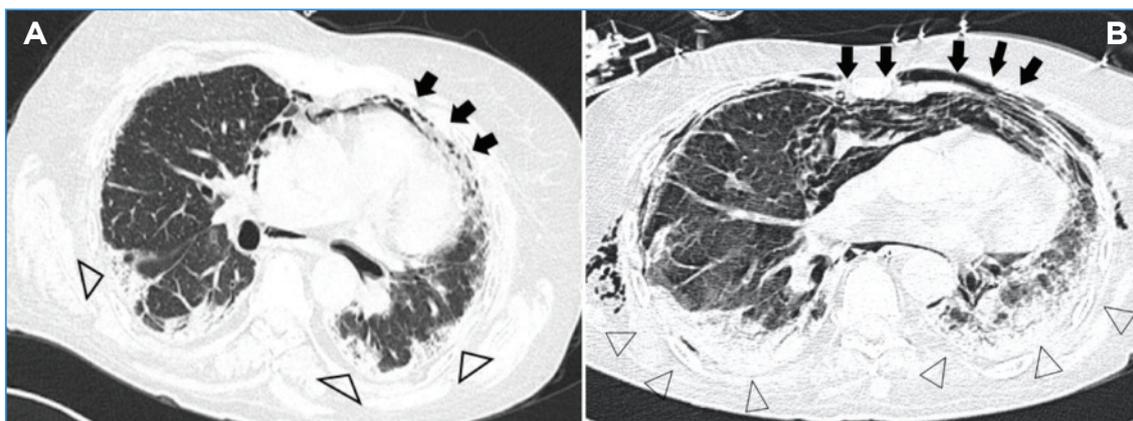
A) Axial image of chest computed tomography 4 months after pneumomediastinum (PnM) diagnosis with a significant reduction of the size of the PnM (black arrows). NSIP (arrow heads). B) Axial image of last performed chest computed tomography 6 months after pneumomediastinum (PnM) diagnosis with a significant worsening of parenchymal lesions and consolidation areas (arrow heads). It is also evident an increase in the size of the PnM (black arrows) and subcutaneous emphysema.
